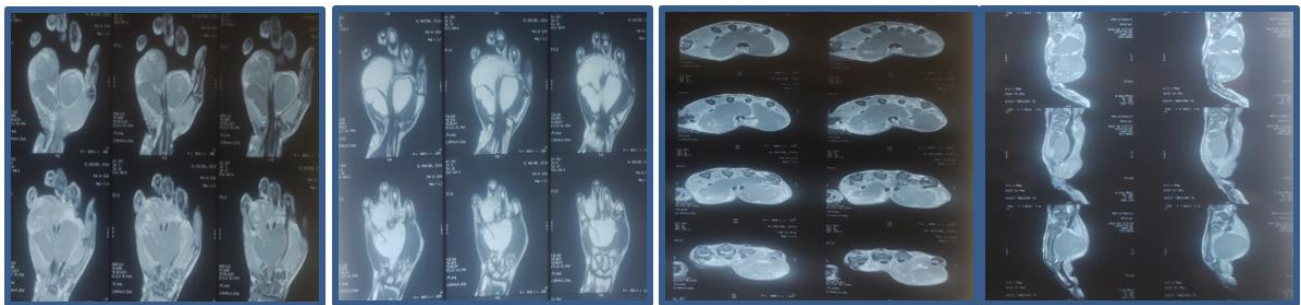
MRI showing the location, volume, appearance and crescent shape of the lipoma
